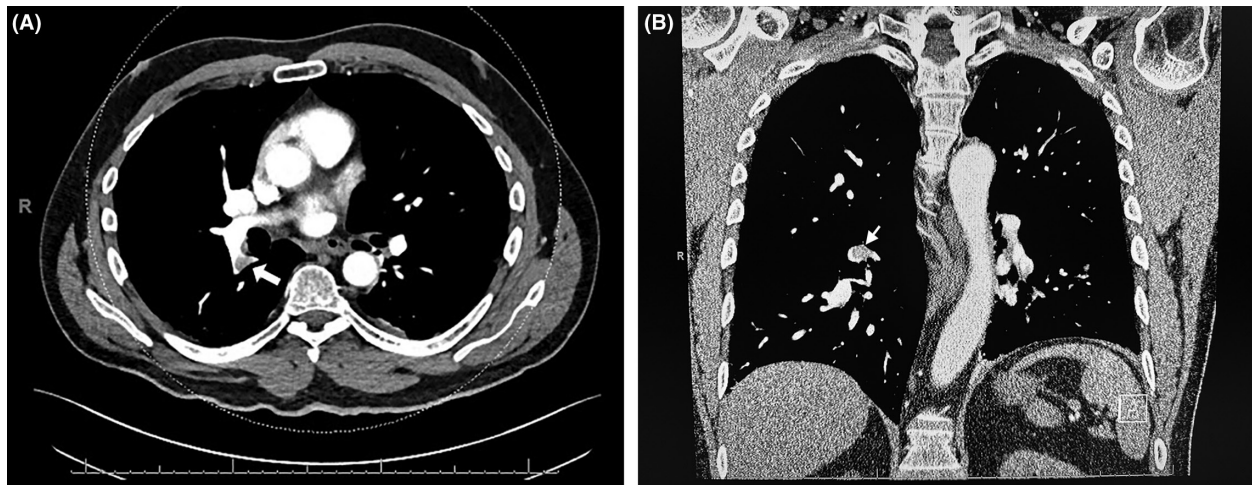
(A) Axial and (B) coronal CT pulmonary angiograms demonstrated bilateral lobar and segmental pulmonary emboli with high clot burden (white arrows). Obtained May 2019.
